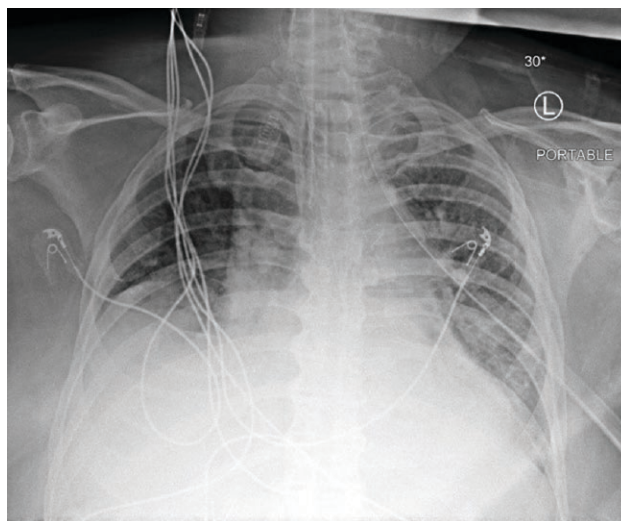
Chest x-ray upon presentation with multifocal opacities.
